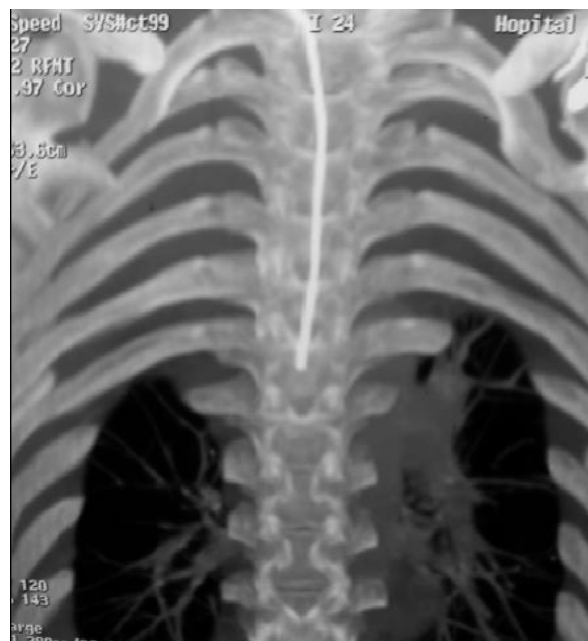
Coronal reformatted CT image of the chest showing the implantable port catheter (arrow) coursing aberrantly into the T1 vertebral body. The catheter track is visible within the medullary cavity of the bone, indicating intramedullary malposition. The port chamber is seen in the right anterior chest wall subcutaneous tissue.
